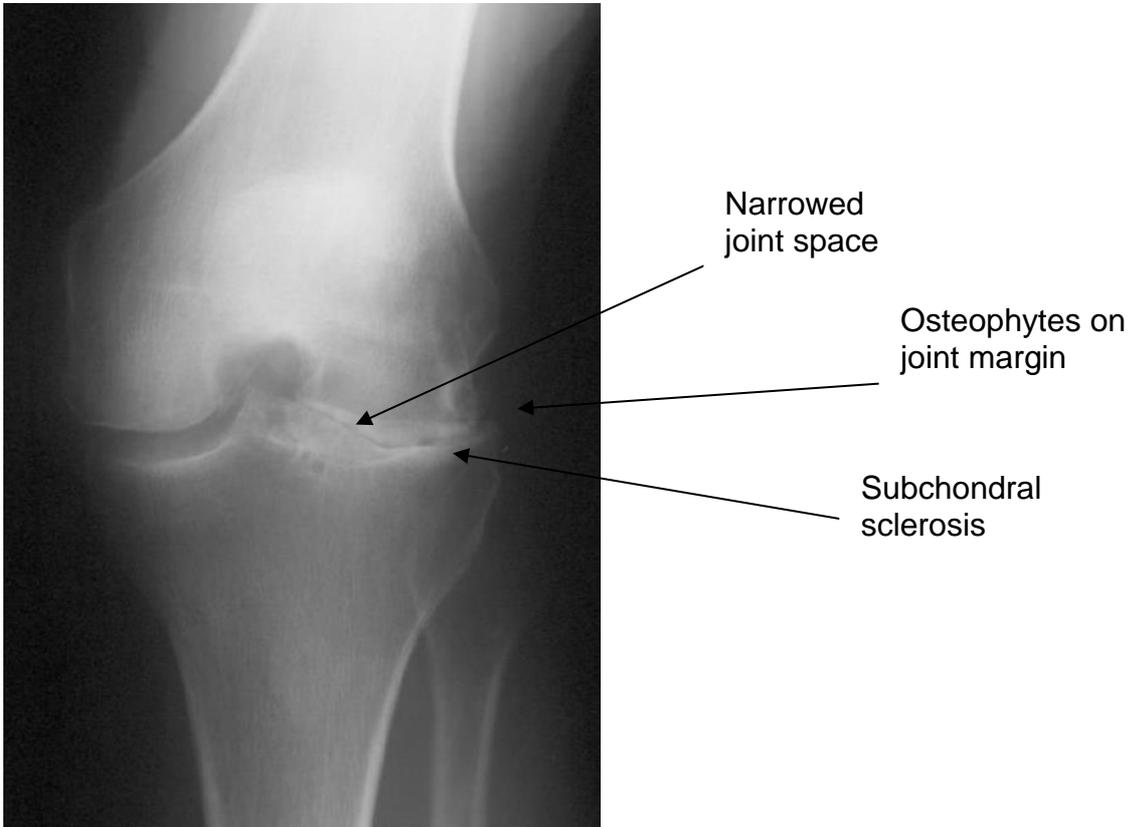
2 A radiograph showing characteristic features of end-stage knee osteoarthritis
